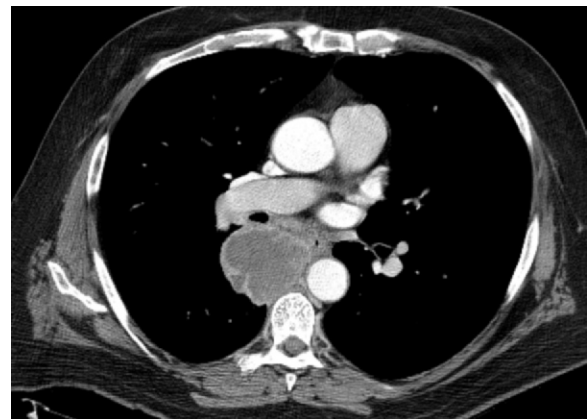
Squamous cell carcinoma in a 58-year-old man with HIV infection (CD4 count = 319 cells/ μ L) who was receiving ART. The patient had a 40-pack-year smoking history and presented with fatigue and dyspnea on exertion. CT image shows a central mass with peripheral enhancement and central necrosis. Biopsy demonstrated squamous cell carcinoma of the lung.
